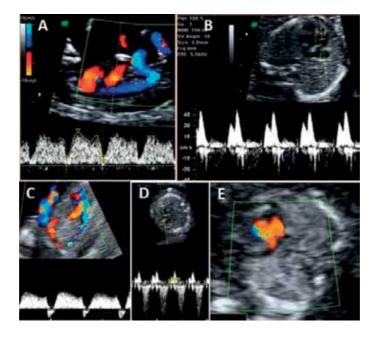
Normal flows at the pulsed Doppler interrogation of ductus venosus (A) and tricuspid valve (B). Ductus venosus with reversed a-wave (C) and tricuspid regurgitation (D) in fetus with atrioventricular septal defect (E).
